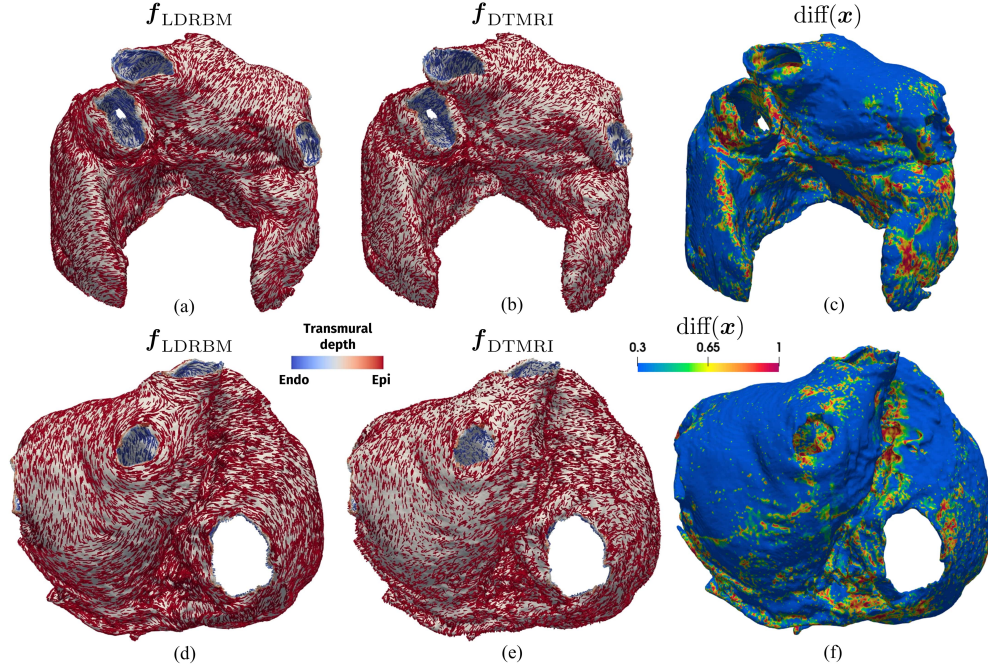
Comparison between the atrial LDRBM fibers and the DT-MRI fiber data, in a reconstructed biatrial real geometry. Left: Fiber vector fields \mathbf{f} are rendered in Glyphs for LDRBM (a-d) and DT-MRI data (b-e) in the anterior (a-b) and posterior view (d-e). Right: differences between LDRBM and DT-MRI fibers, computed as $\text{diff}(\mathbf{x}) = 1 - |\mathbf{f}_{\text{DTMRI}}(\mathbf{x}) \cdot \mathbf{f}_{\text{LDRBM}}(\mathbf{x})|$. Colour-bar saturated for values $\text{diff} \geq 0.3$. Top: frontal view; Bottom: anterior view.
